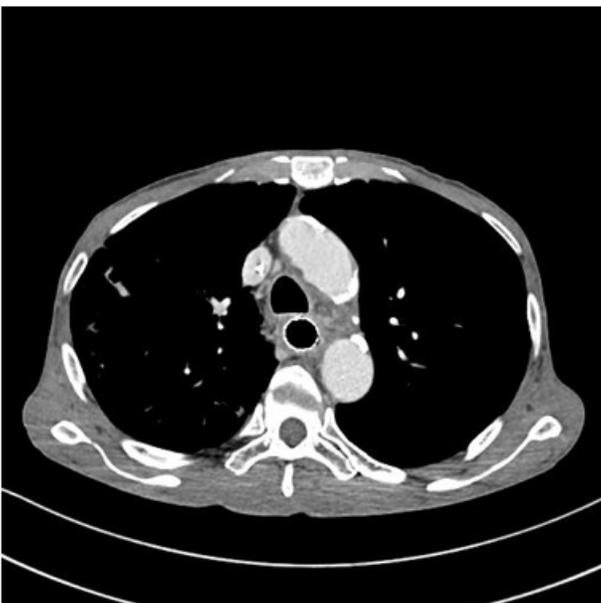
At 6 months after chemoradiotherapy contrasted CT showed partial response at primary site.
